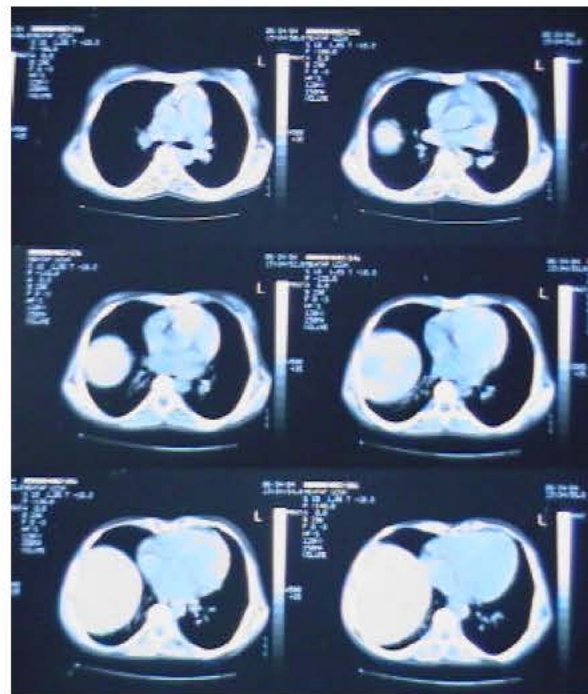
CT slices of her thorax shows only the elevated right diaphragm without any mediastinal mass or parenchymal lesions
